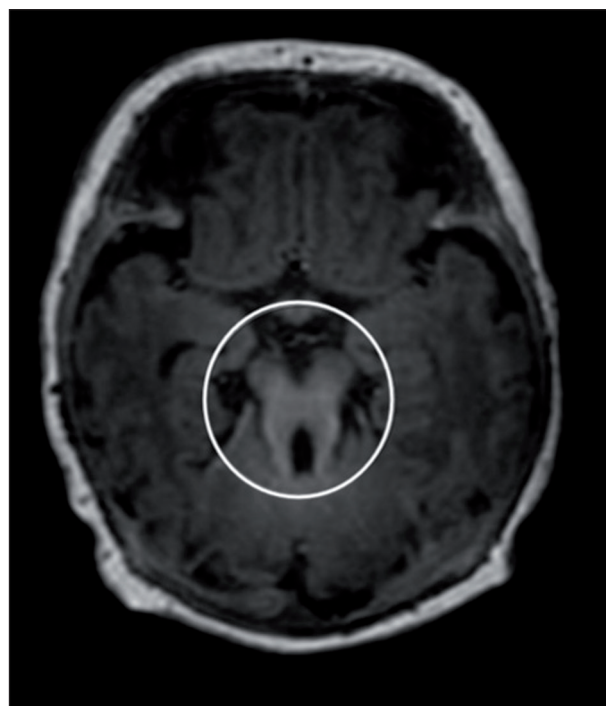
Brain magnetic resonance image (T1-weighted imaging, axial plane) showing the characteristic “molar tooth” sign of the mesencephalon in Joubert syndrome (JS) (circled).
